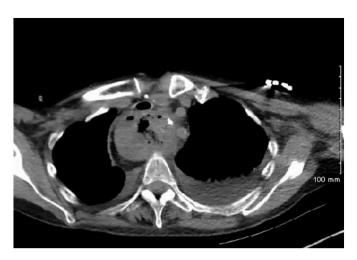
Axial non-contrast CT at the level of the gastric conduit.
